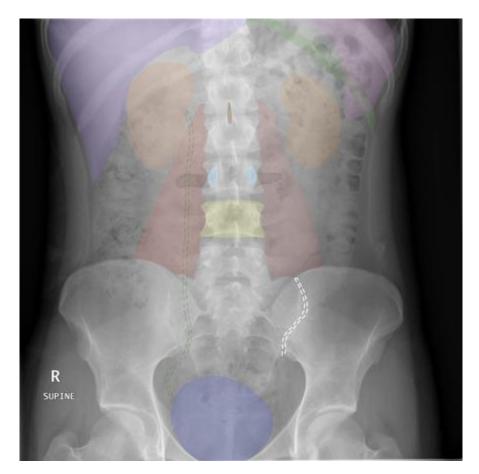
X-ray of the abdominal organs
